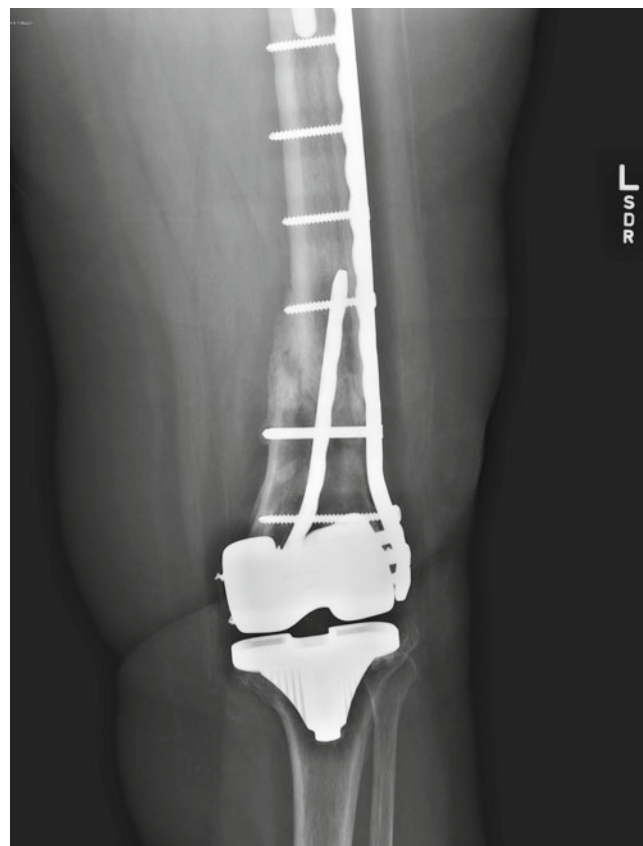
AP knee X-ray of fixation with lateral plating of a periprosthetic femur fracture. In this instance, a second (intramedullary) plate was used for added stability
